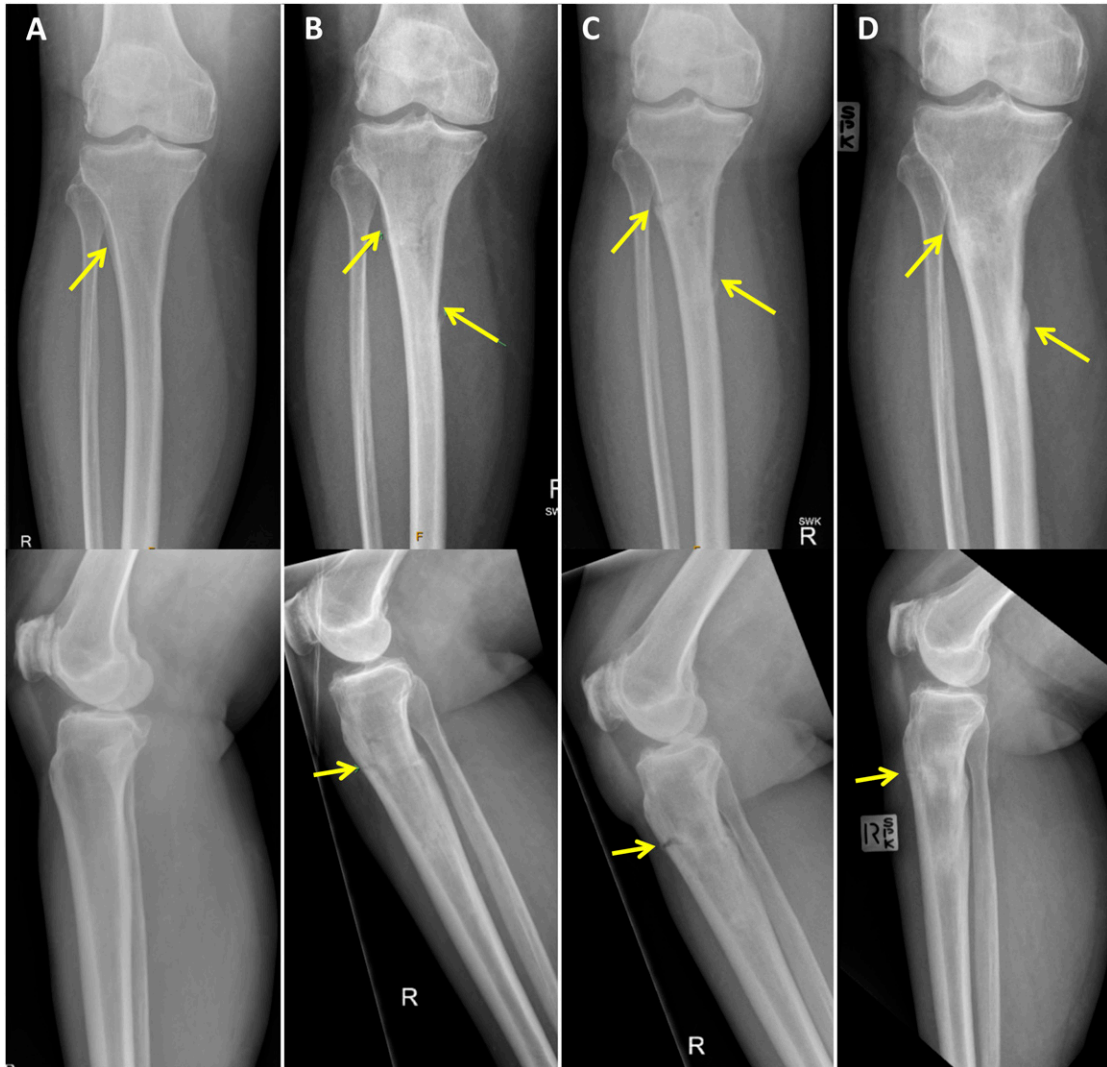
Radiographs showing evolution of APTF in HPP. (A) Radiograph at her initial presentation with pain showing only periosteal reaction along the proximal tibial shaft. (B) Radiograph 1 mo later showing a nondisplaced pathological fracture through the proximal tibial shaft and extending inferiorly through the metaphysis (*arrows*) with periosteal reaction in the lateral tibial cortex. (C) Radiograph 2 mo after presentation showing a more conspicuous fracture line, with evidence of early callus formation. (D) Radiograph 6 mo after fracture showing bony union with mature callus.
